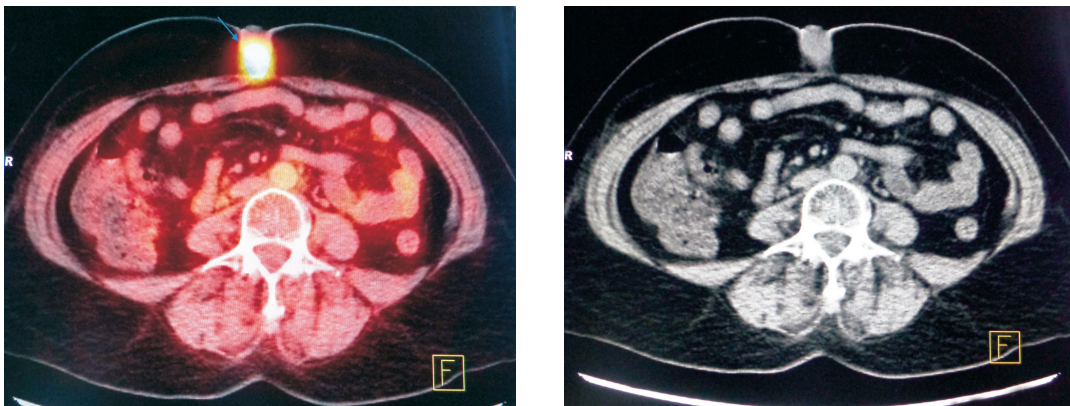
PET-CT of the umbilical nodule
